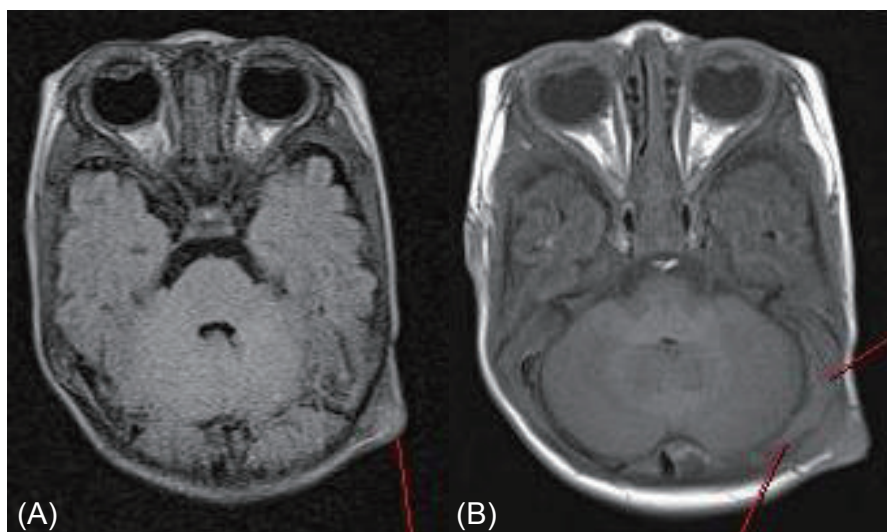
(A) T2-weighted MRI of brain revealed 1.4×1.1 cm sized peripheral rim enhancing mass at left occipital area. (B) The thickness of dura mater was consistent with dura extension of scalp abscess in T1-weighted image.
